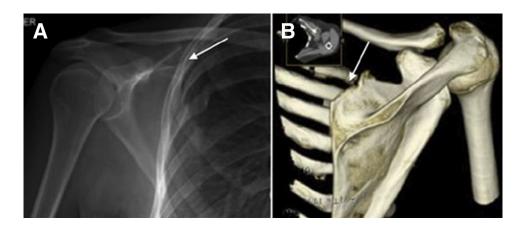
Anteroposterior shoulder radiograph (A) and 3-dimensional computed tomography reconstruction (B) of a right shoulder after primary arthroscopic scapuloplasty and bursectomy before the revision surgical procedure. The resected superomedial scapula angle (arrows) can be seen without heterotopic ossification. (Reprinted with permission.⁹)
